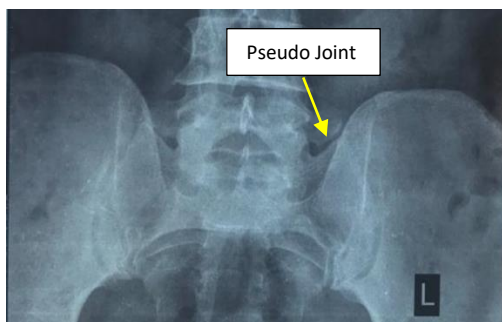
X-ray Lumbosacral spine showing pseudo joint between L5 transverse process, sacral ala and ilium
